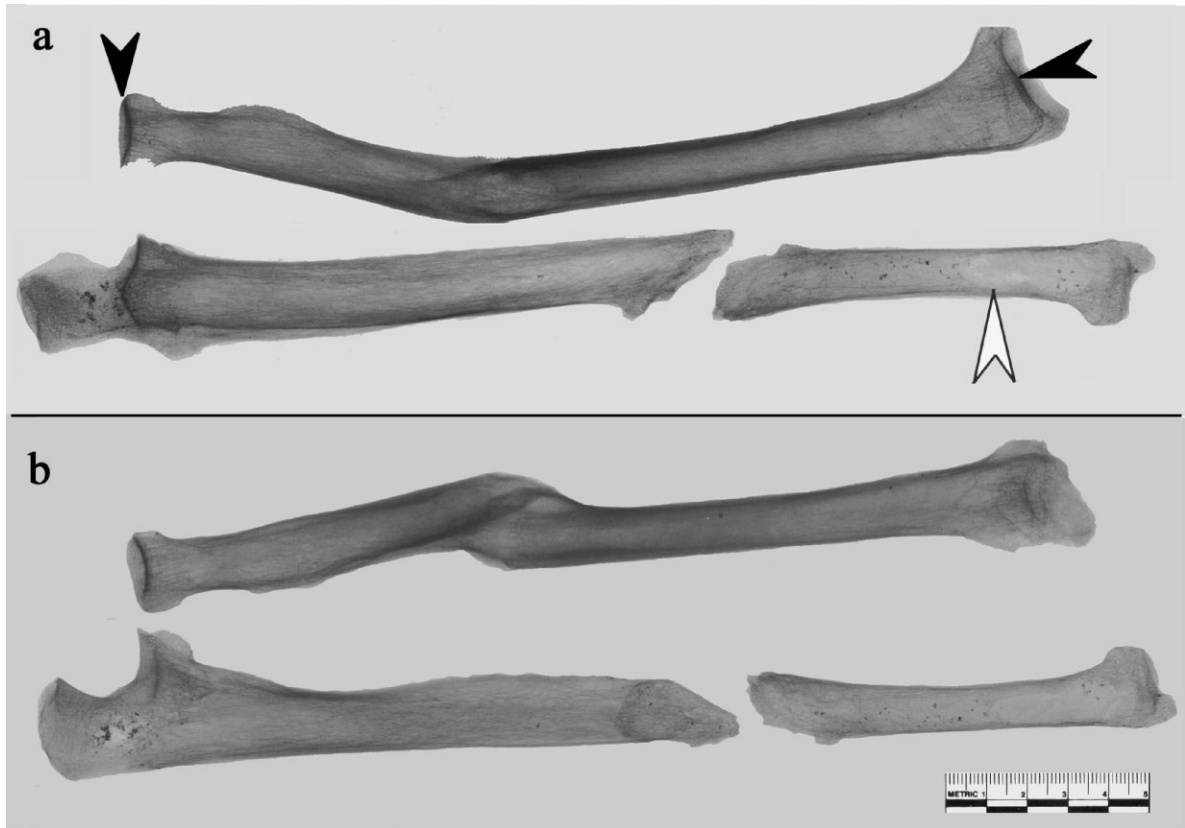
(a) Anterior-posterior radiograph of right radius and ulna and (b) medial-lateral radiograph of right radius and ulna. The white arrow points to a post-depositional radiolucency on the ulna as noted in text. Black arrows point to areas of reactive bone as noted in text.
